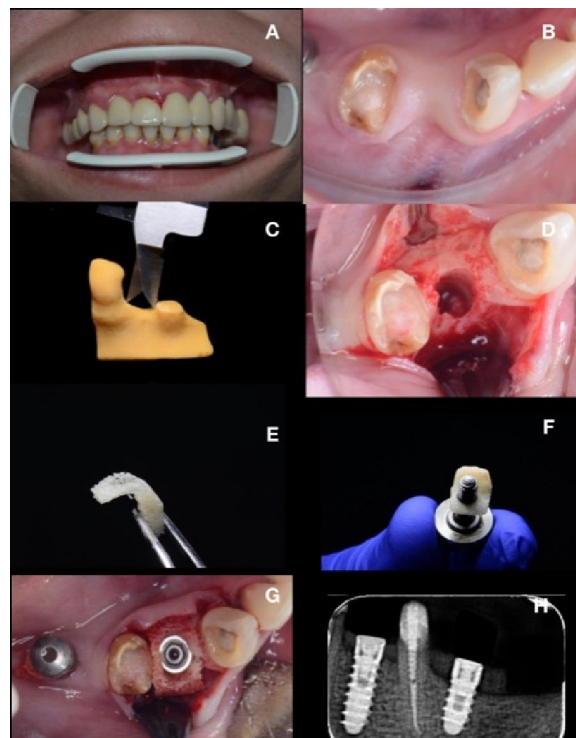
A: preoperative frontal photo B: Occlusal view of the surgical defect C: 3D printed model D: osseotomy & site preparation E: xenogenic bone block F: xenogenic block fixed to the implant G: occlusal view for the block graft fixed with the implant H: immediate postoperative periapical xray.
